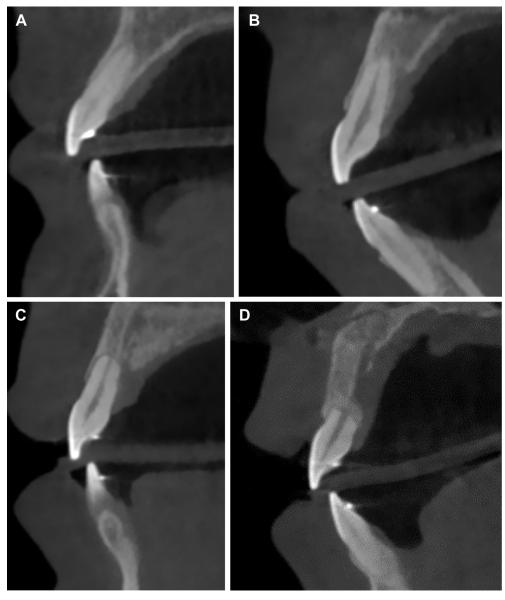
Levander classification. This figure depicts 4 sagittal cone-beam computed tomography images of maxillary central incisors corresponding to the 4 classes of the Levander classification. *A*, Class 1 root resorption includes an irregular root contour. *B*, Class 2 amounts up to 2 millimeter apical root resorption. *C*, Levander class 3 consists of apical root resorption from 2 mm to one third of the original root length. *D*, Class 4 resorption exceeds one third of the original root length.
